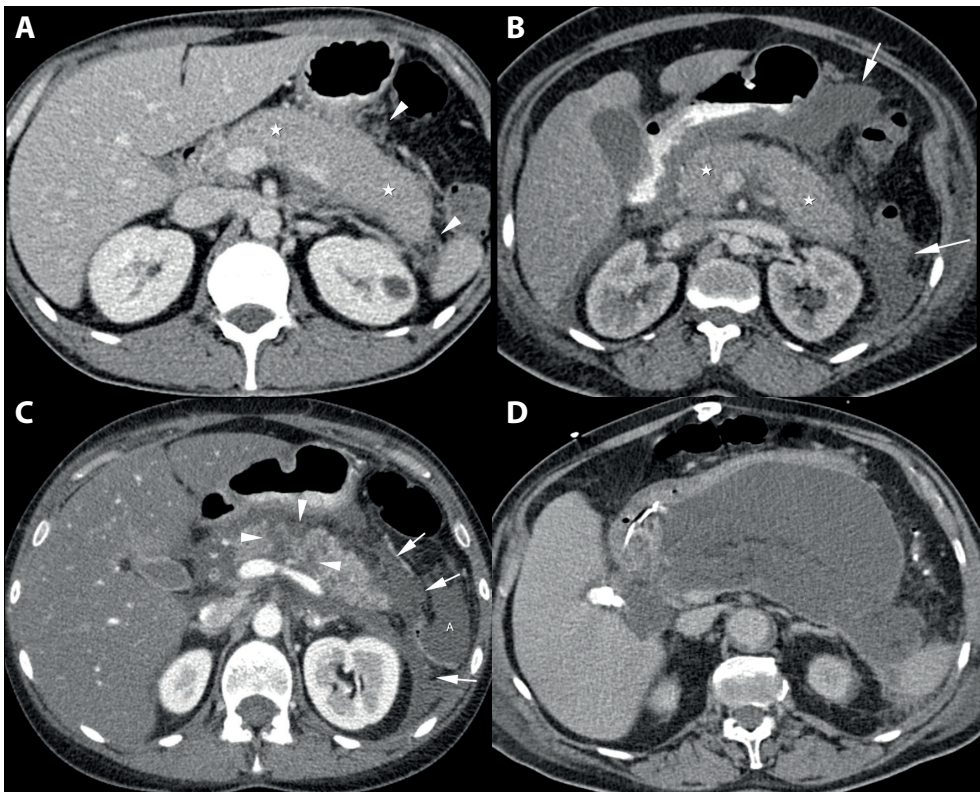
CT severity index. (A) CTSI of 2: swollen but normal enhancing pancreas (asterisks) with little peripancreatic fat stranding (arrowheads). (B) CTSI of 4: normal enhancing pancreatic parenchyma (asterisks) with more than 2 collections (arrows). (C) CTSI of 6: less than 30% nonenhancing pancreatic parenchyma at the level of pancreatic body (arrowheads) with associated necrotic collections (arrows); A: ascites in the left paragolic gutter. (D) CTSI of 10: extensive necrosis of more than 50% of pancreatic parenchyma with associated necrotic collections. Note, calcified stones in the gallbladder.
